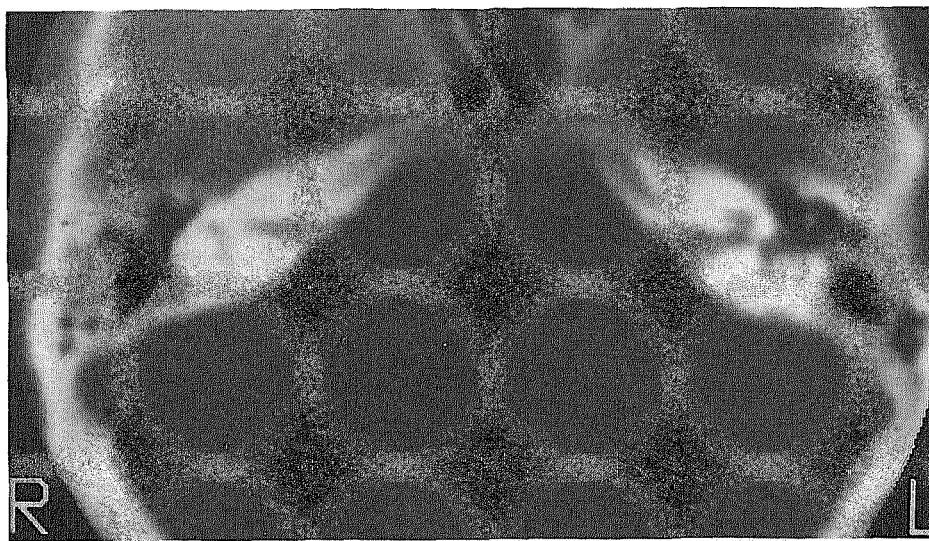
Left acoustic neuroma. Axial CT section demonstrating funnel-shaped enlargement of the left internal auditory canal.
